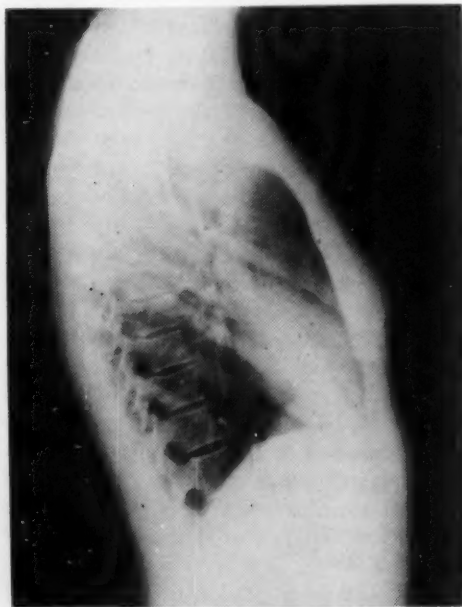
A typical radiograph photographed by transmitted light upon an x-ray illuminator.
